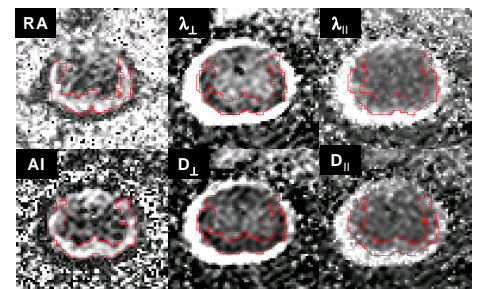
Images of mildly injured cord. Top row: six-direction DTI maps. Bottom row: two-direction DWI maps. ROIs indicate the region of residual white matter.
